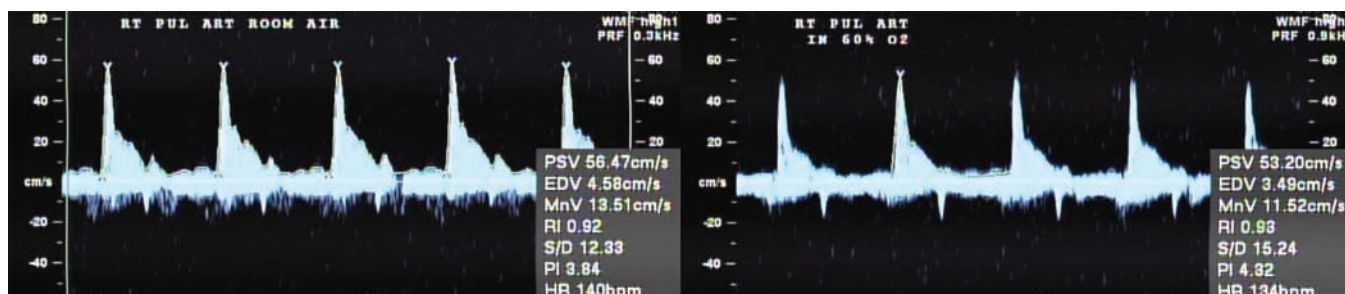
Negative change in Doppler flow patterns of pulmonary vascular reactivity with oxygen.
